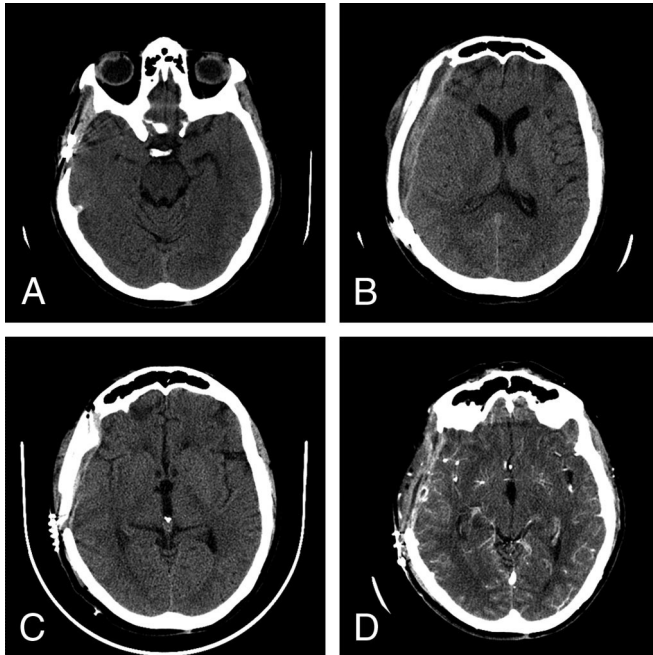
Computed tomographic scans. *A*, Resorbed right frontoparietal autologous skull. *B*, After revision cranioplasty with an acrylic plate. *C*, Subdural fluid collection with symptoms. *D*, After craniectomy, with improved symptoms.
